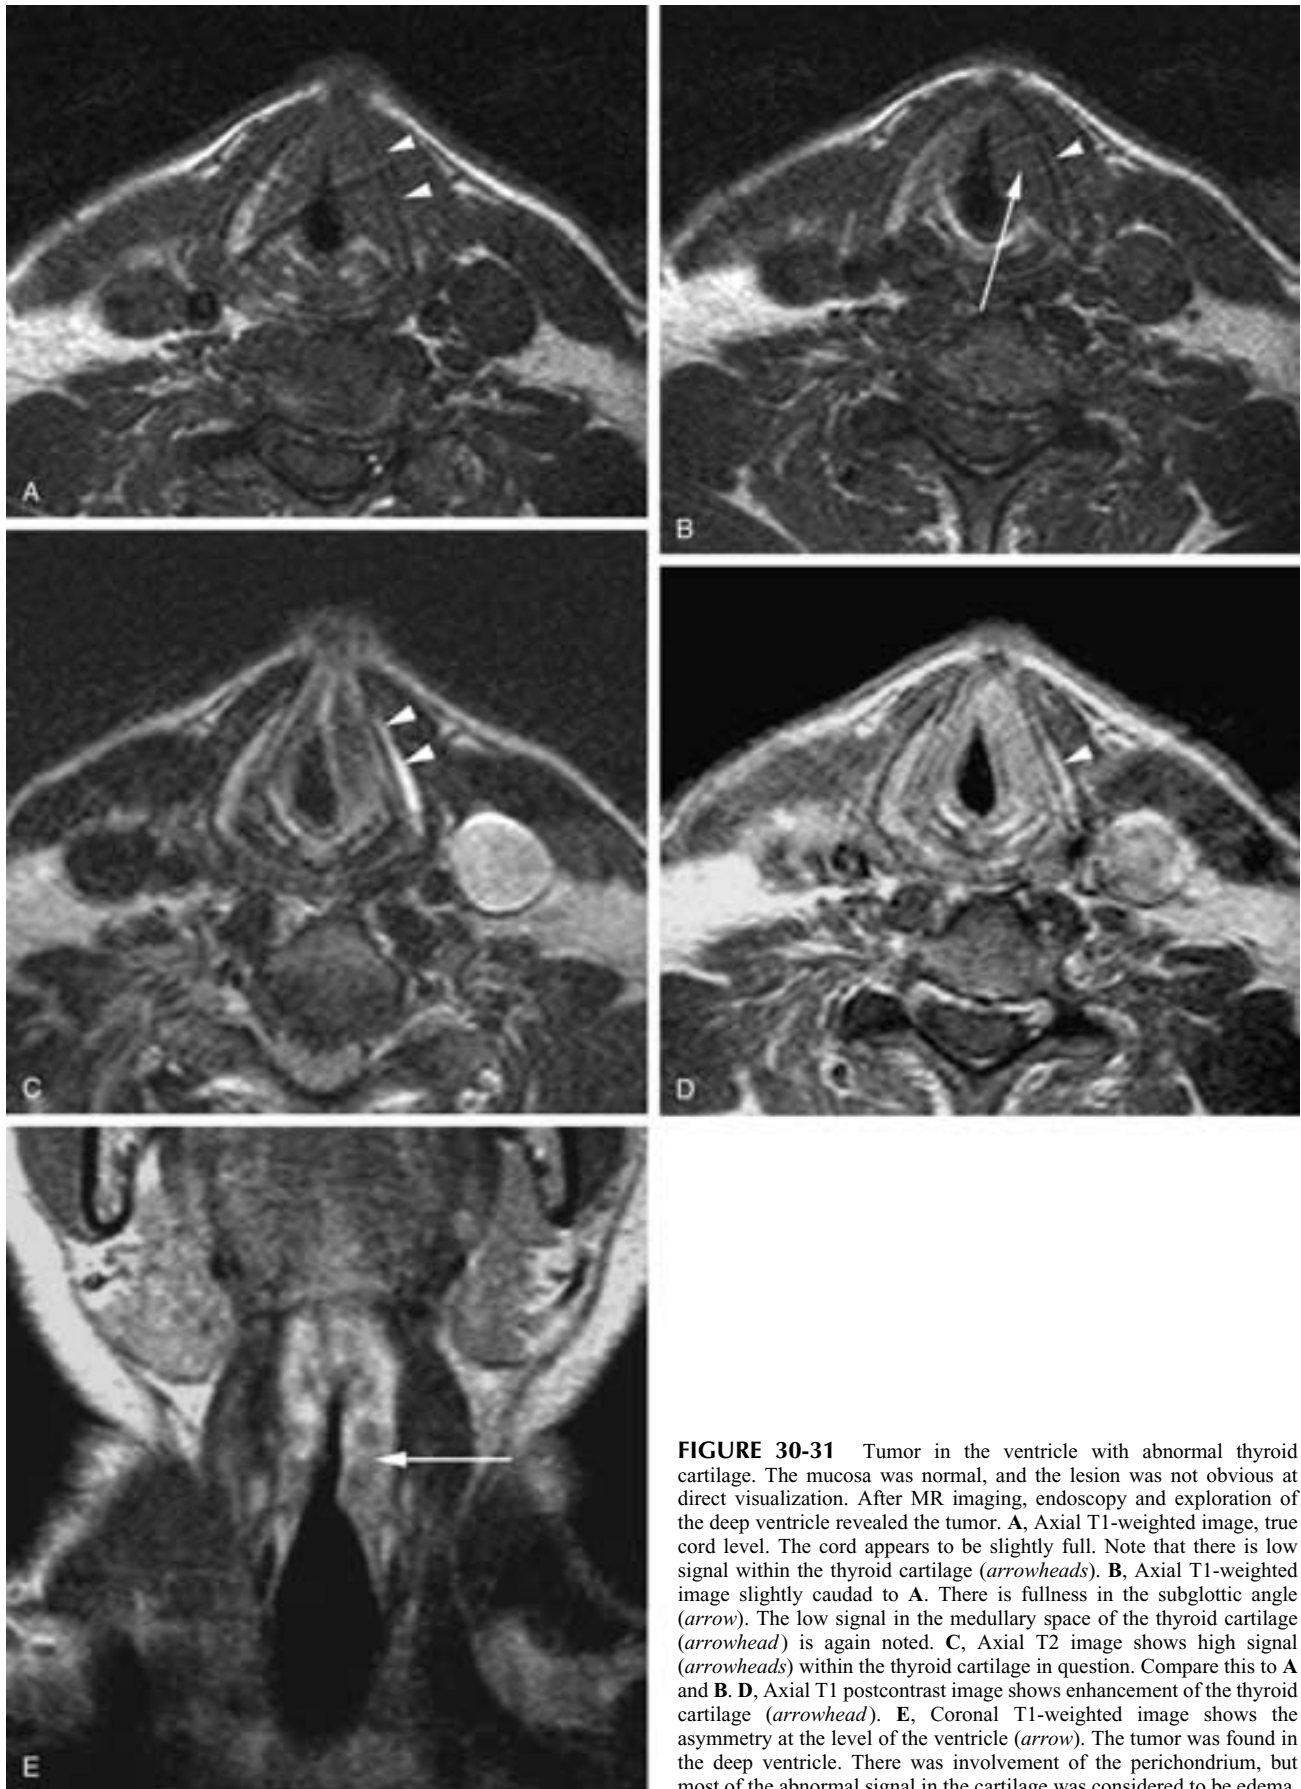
Tumor in the ventricle with abnormal thyroid cartilage. The mucosa was normal, and the lesion was not obvious at direct visualization. After MR imaging, endoscopy and exploration of the deep ventricle revealed the tumor. A, Axial T1-weighted image, true cord level. The cord appears to be slightly full. Note that there is low signal within the thyroid cartilage (*arrowheads*). B, Axial T1-weighted image slightly caudal to A. There is fullness in the subglottic angle (*arrow*). The low signal in the medullary space of the thyroid cartilage (*arrowhead*) is again noted. C, Axial T2 image shows high signal (*arrowheads*) within the thyroid cartilage in question. Compare this to A and B. D, Axial T1 postcontrast image shows enhancement of the thyroid cartilage (*arrowhead*). E, Coronal T1-weighted image shows the asymmetry at the level of the ventricle (*arrow*). The tumor was found in the deep ventricle. There was involvement of the perichondrium, but most of the abnormal signal in the cartilage was considered to be edema.
